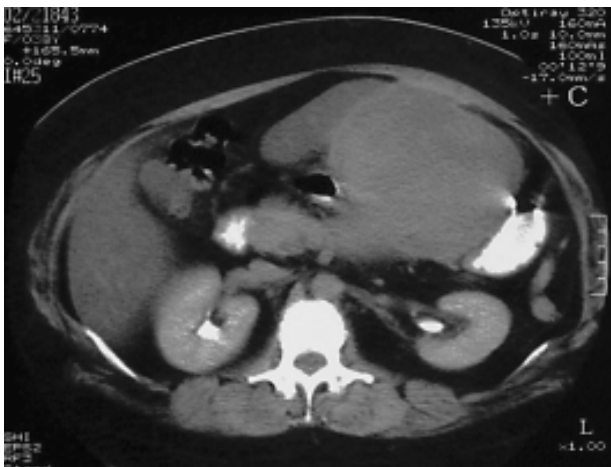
CT of the abdomen and abdominal wall.
